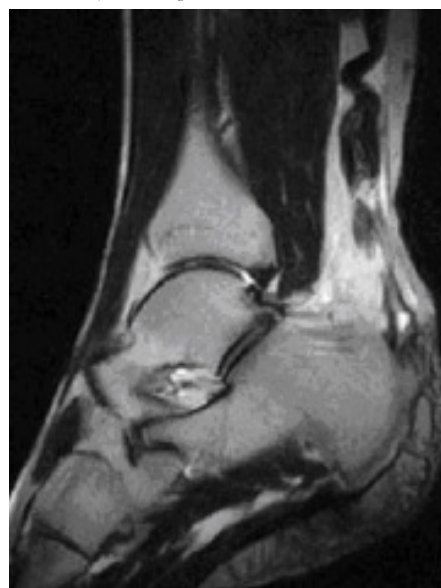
MRI of ankle joint in Achilles tendon rupture
